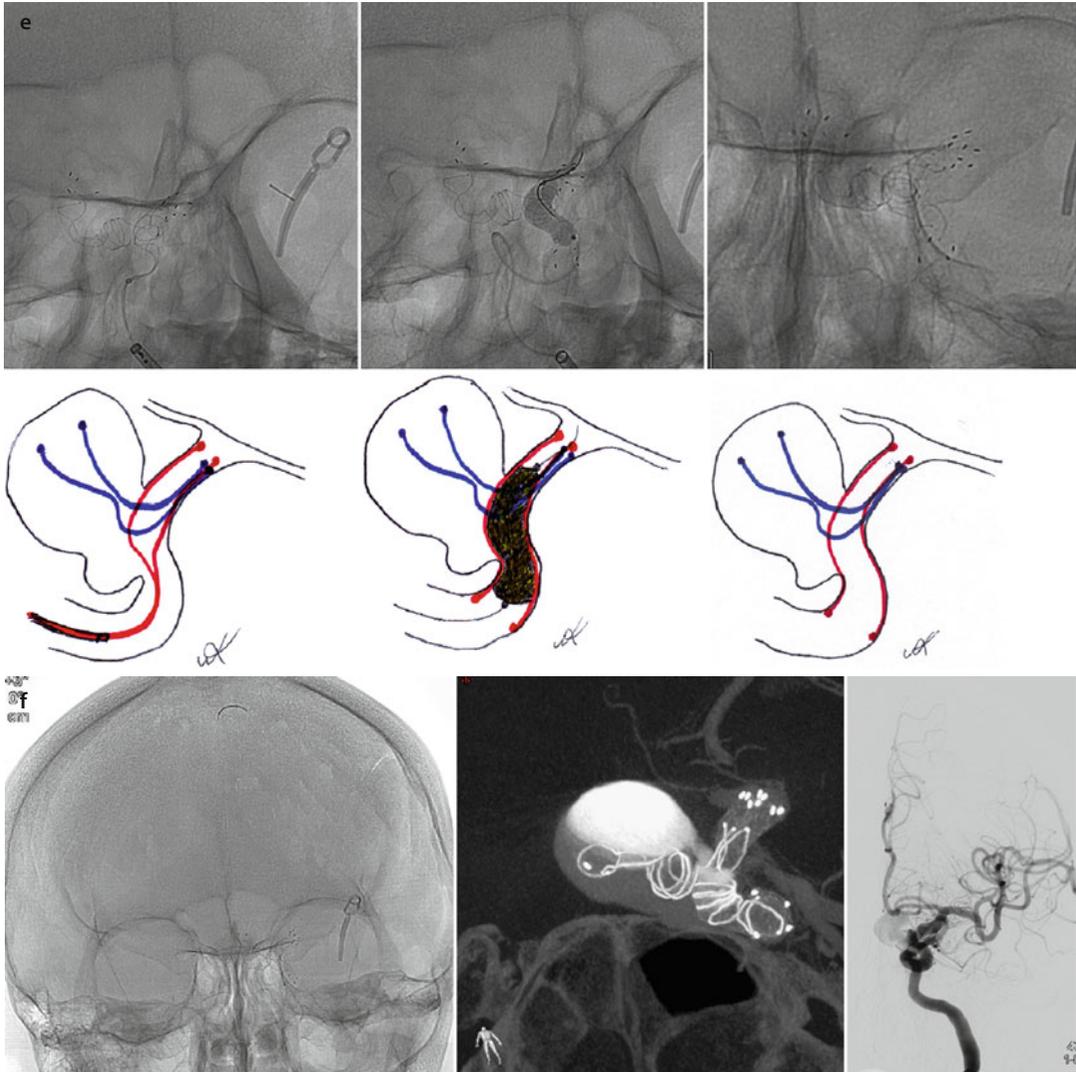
(continued) (e) Another $4.5 \times 25 \times 18$ mm-sized FRED[®] was then deployed adjacent to the previously deployed FRED[®] and the aneurysmal neck. This was done, as the author was confident about the high radial strength of FRED[®]. A 4×15 mm-sized hyperglide[®] (ev3, Irvine, CA) balloon was navigated into this second FRED[®], and angioplasty was done to ensure stent apposition to the ICA wall. Post-balloon angioplasty, there is near-normal caliber of the stented ICA. (f) Immediate postprocedural angiograms and IA VASO CT[®] demonstrate decreased aneurysmal filling, good stent wall apposition, and the compressed first FRED[®] that is extending from distal ICA to aneurysm
